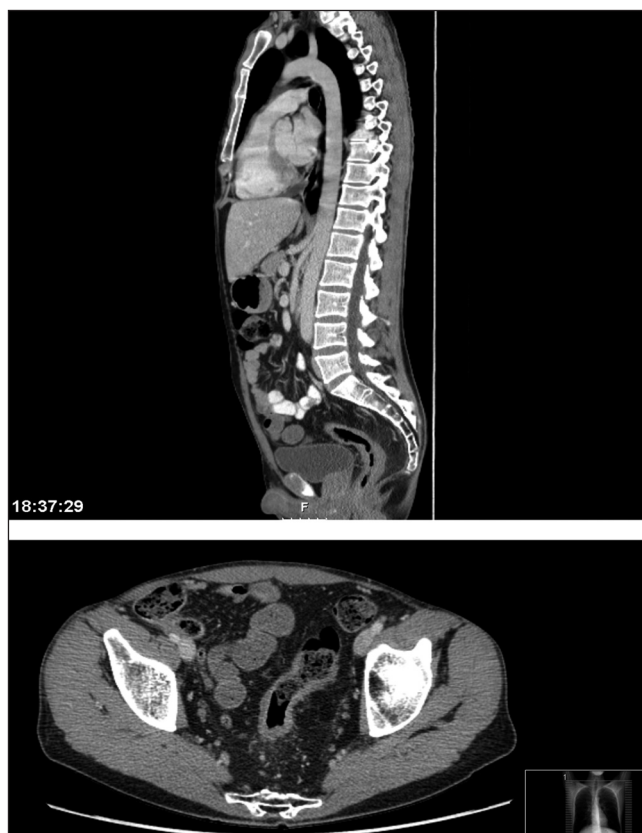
Contrast-enhancement computed tomography where we can observe thickening of the rectum and sigmoid.
